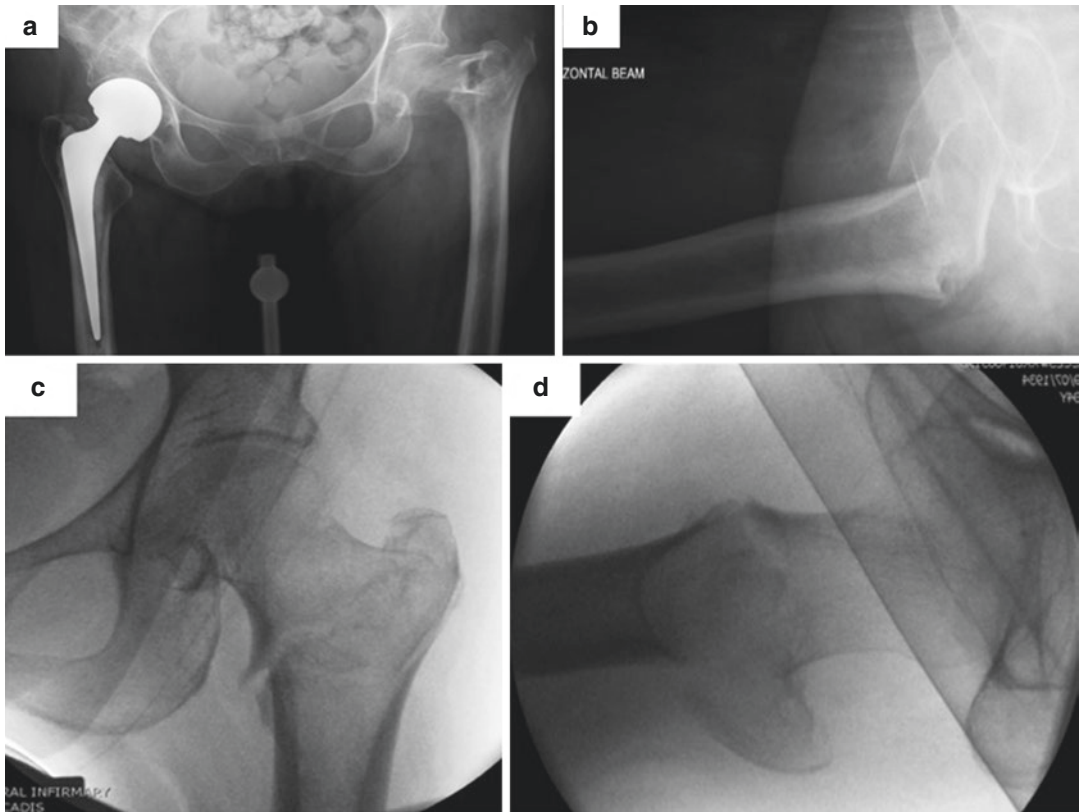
Preoperative (a) AP pelvic and (b) lateral radiographs demonstrating a left displaced pertrochanteric hip fracture. (c) AP and (d) lateral fluoroscopic images of the left hip showing improved alignment after closed reduction
